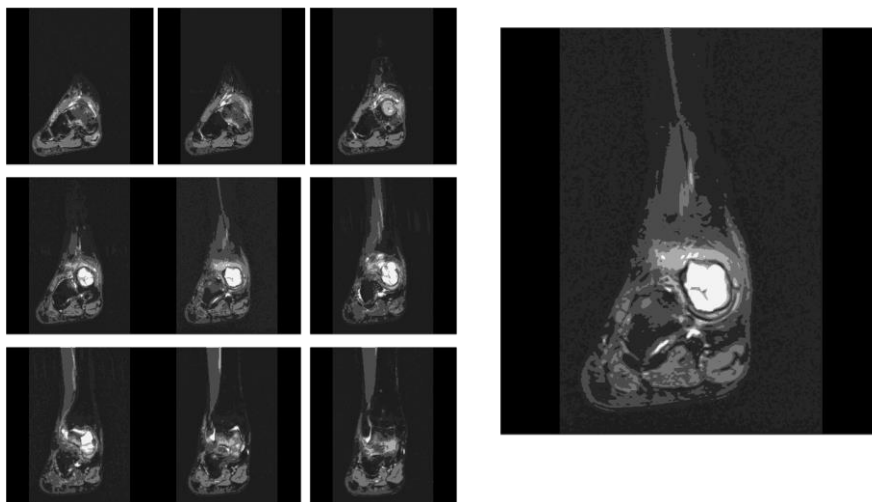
Right Ankle MRI T2W Coronal View.
